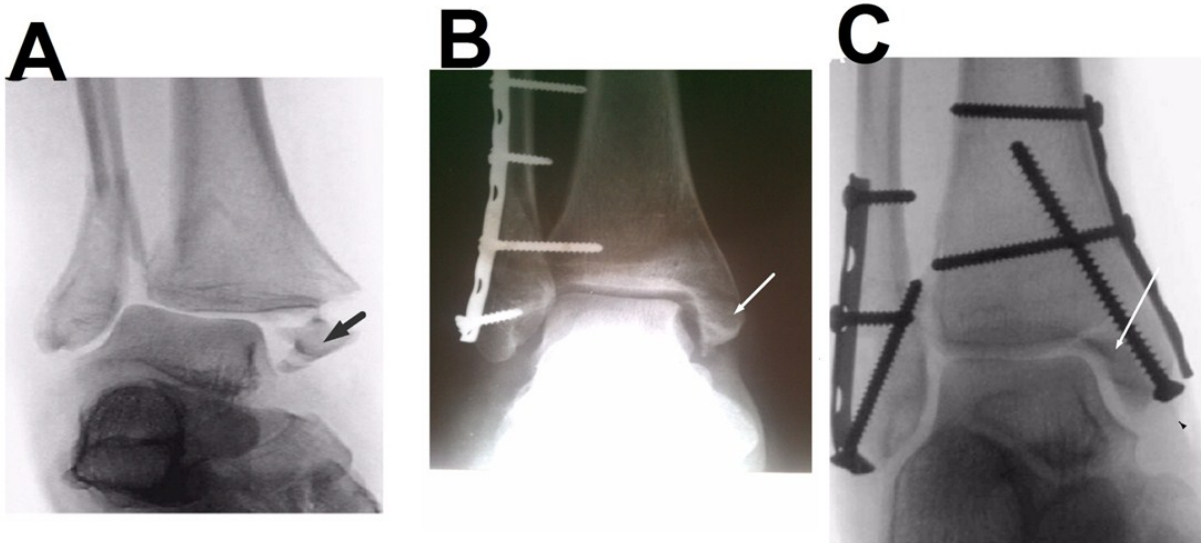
Radiographs of A) pre-operative fractures with an arrow (black) showing the medial malleolus; B) post-operative treatment without medial malleolus screw(s) indicated by the arrow (white); C) post-operative treatment with medial malleolus screw(s) indicated by arrow (white).
